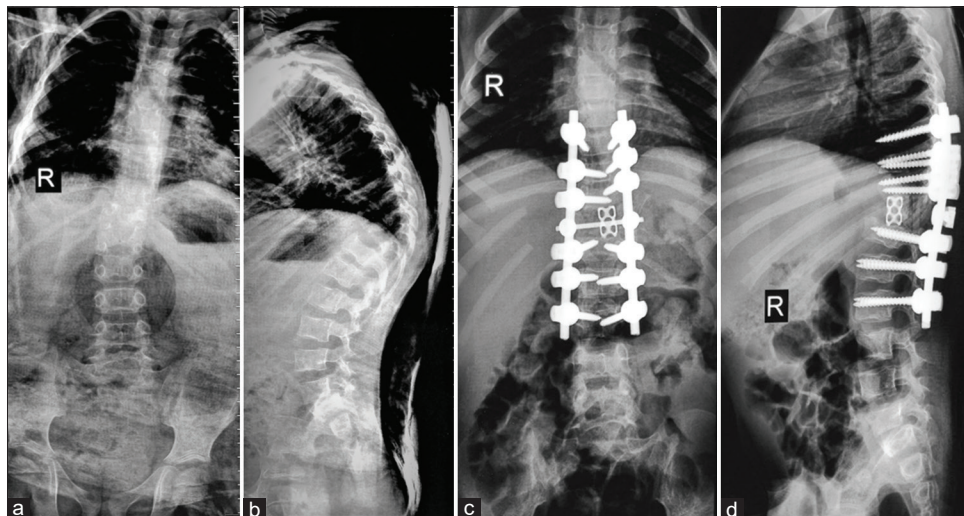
(a) X-ray AP view showing Tuberculosis of dorsal spine. (b) X-ray lateral view showing tuberculous of dorsal spine. (c) Postoperative X-ray at 3 months. (d) Postoperative X-ray at 3 months
